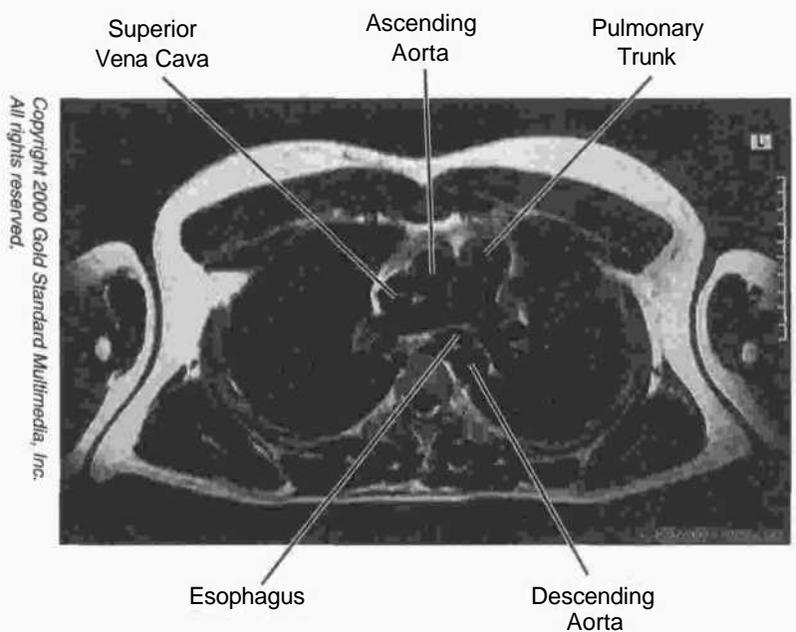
Chest: MRI, Axial T₄
